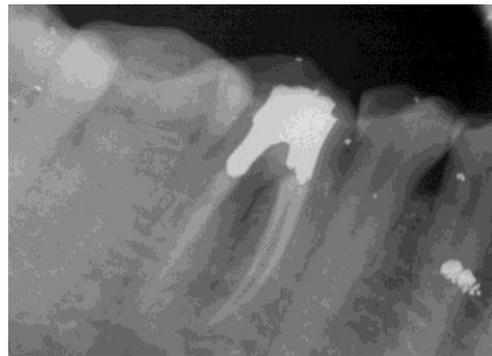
Radiograph at 9 months showing bone fill in furcation area.
